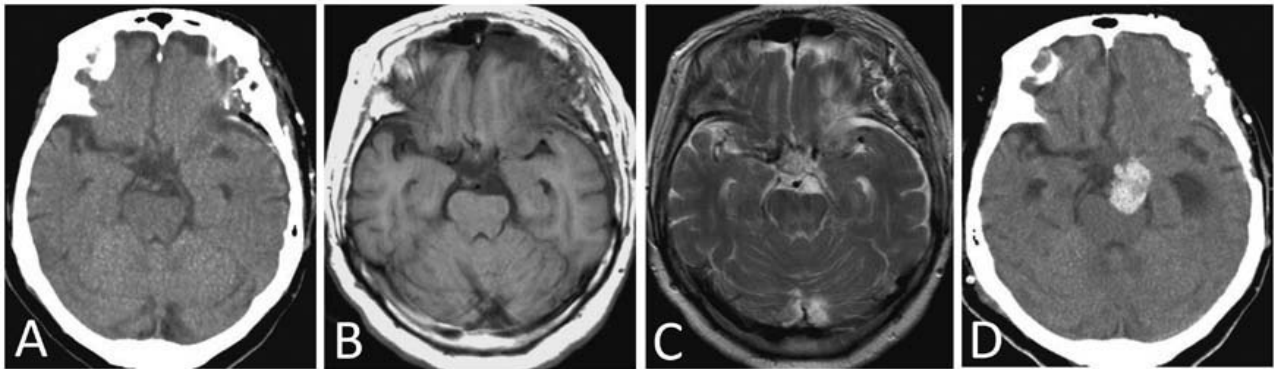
A-C) Postoperative unenhanced axial CT (A), T_1 -weighted MRI (B) and T_2 -weighted imaging (C) showing successful evacuation of cyst fluid. D) One month after first operation, axial unenhanced CT shows hematoma from the residual tumor compressing the brainstem and also causing non-communicating hydrocephalus.
